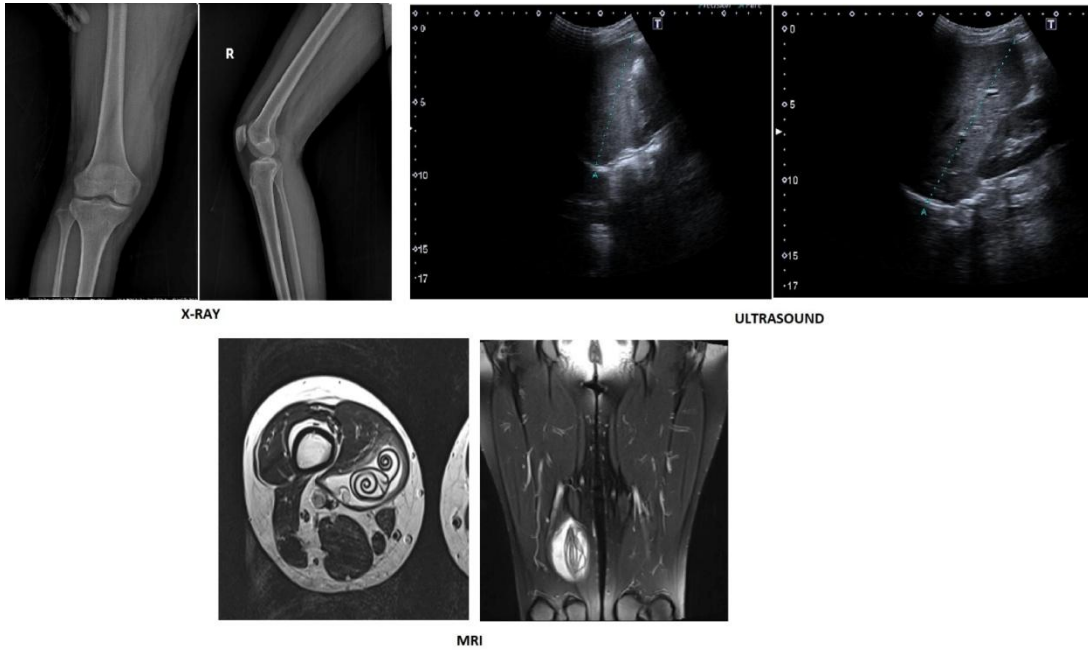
Imaging the location of the muscular hydatid cyst in the vastus medialis (x-ray, ultrasound and MRI)
